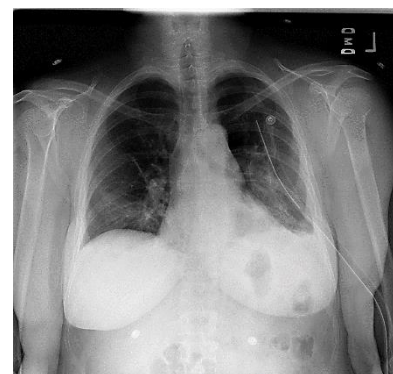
Infiltration Chest X-ray
